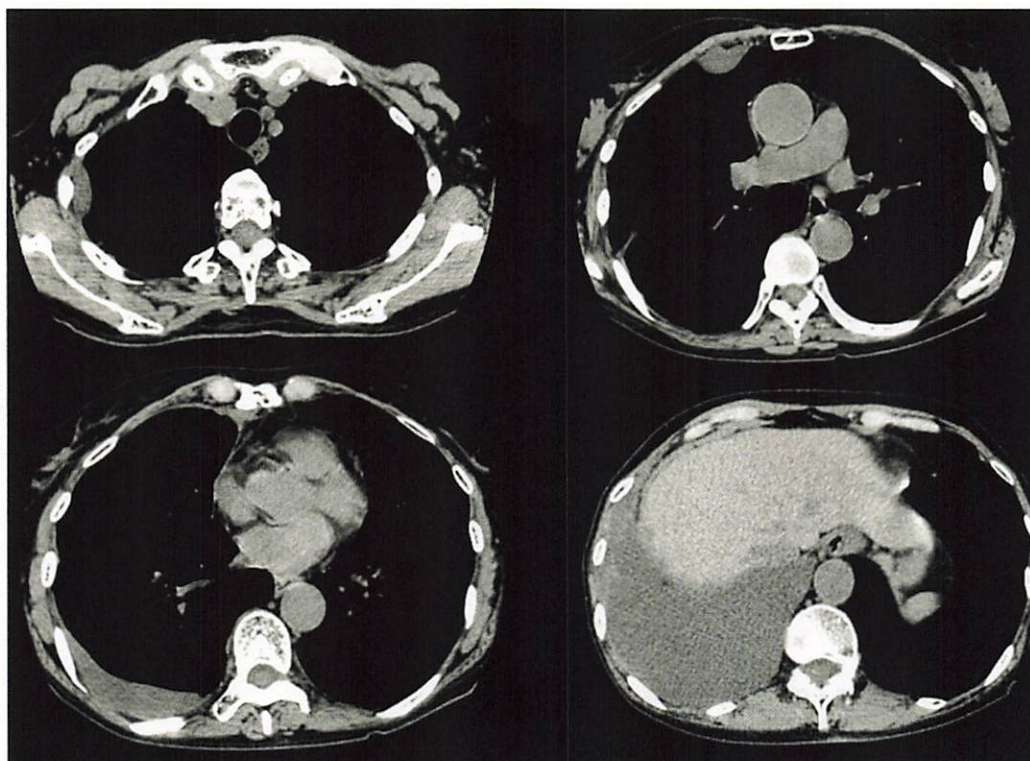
Chest plain CT scans at the first examination by the previous hospital (July 2007)
